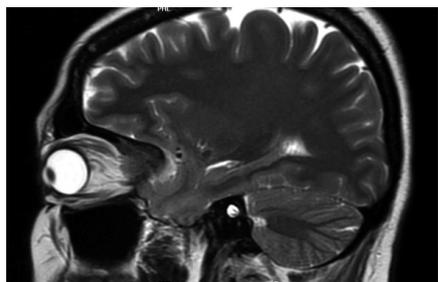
Magnetic resonance imaging of head (sagittal T2-weighted FRFSE sequence) showing meningioma extending to the orbit. Courtesy of the Department of Diagnostic Imaging, University Hospital in Krakow
